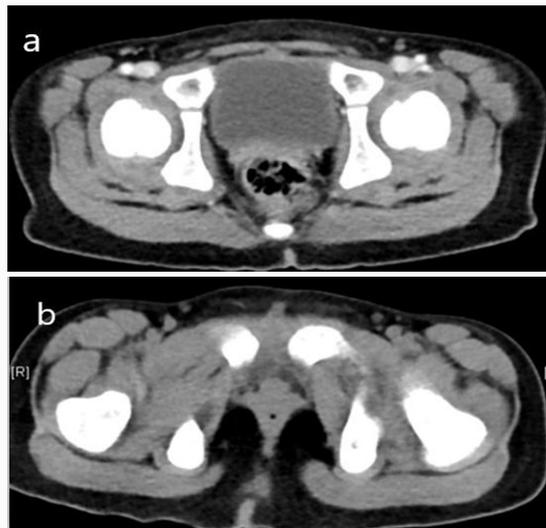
Pelvic CT shows a) a tubular structure near urinary bladder b) widening of pubic symphysis.
